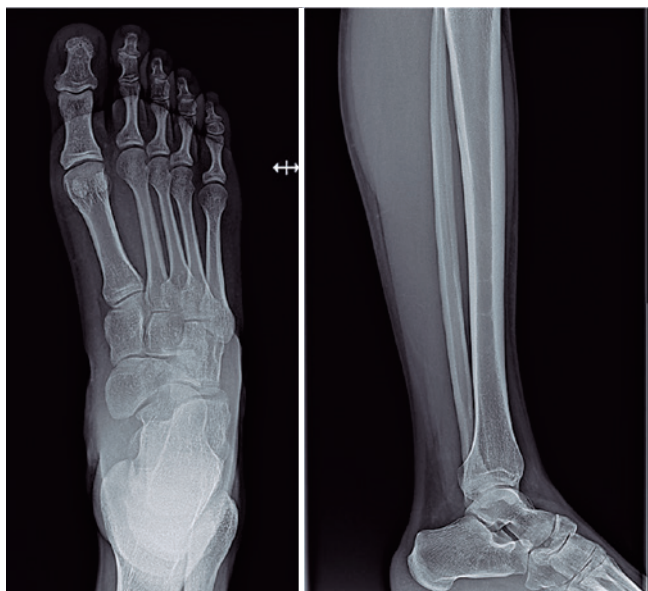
Initial radiographs of the foot and the ankle showing comminuted and displaced fracture of the navicular.
